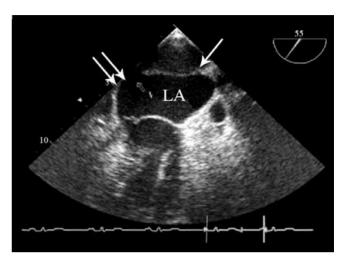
In transesophageal echocardiography, mid-transesophageal view demonstrates the dividing membrane in the left atrial cavity with a small orifice (11 mm) (arrow)
